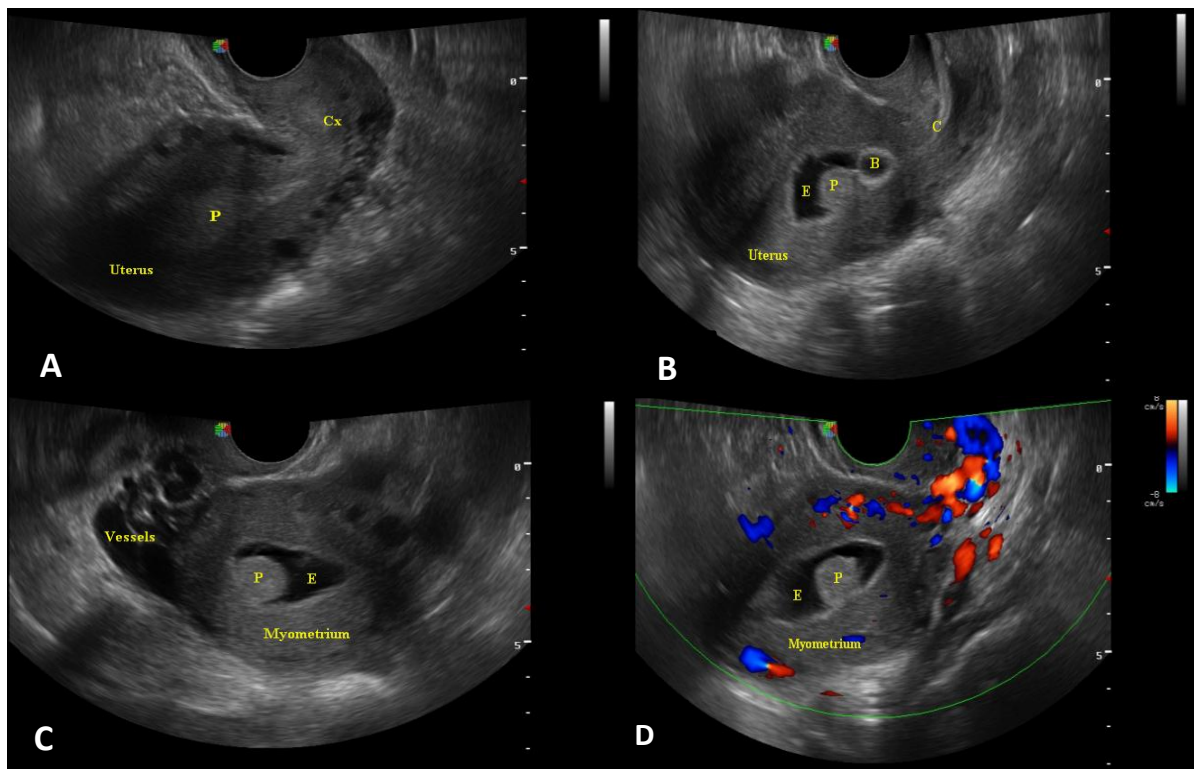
Endometrial polyp: a 33 year old lady with primary infertility, sagittal and axial transvaginal ultrasound showing small posteriorly located intracavitary echogenic well defined pediculated polypoid lesion. Myometrial-endometrial interface is well outline suggesting endometrial nature of the lesion. The lesion is an ill-defined and difficult to appreciate clearly on pre-saline infusion image (A) but well depicted on post-saline infusion images as well as the other portion of the endometrium with normal thickness (B-D), [P=polyp, Cx=cervix, E=endometrial cavity filled with saline, B=balloon, C=catheter]. Tikur Anbessa Hospital, 2019G.C.
